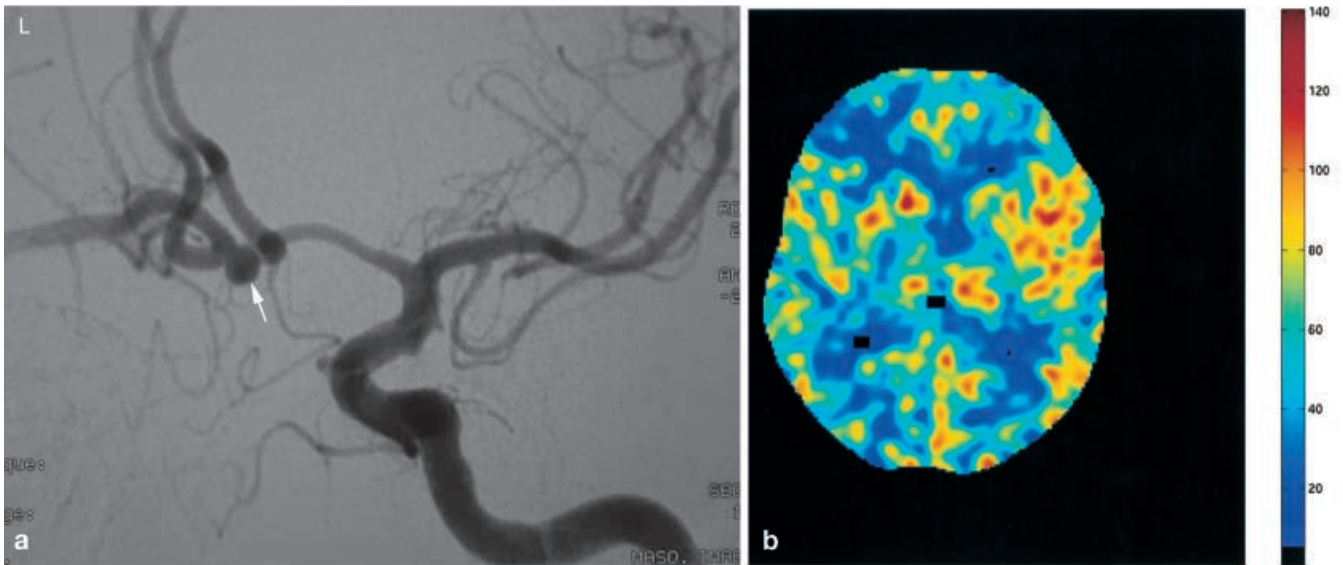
A 53-year-old male patient with chronic arterial hypertension who was admitted to our institution for a subarachnoid hemorrhage. a Lateral angiographic view relates this subarachnoid hemorrhage to a ruptured bilobulated sacciform aneurysm lying on the anterior communicating artery (*arrows*). This aneurysm was clipped surgically. In his follow-up, the patient developed symptomatology of brain ischemia, which justified brain perfusion imaging, i.e., perfusion CT and angiographic studies. The cerebral vessels turned out to be normal. b Stable-xenon CT study obtained 5 min prior to the perfusion CT led to an rCBF map, which can be considered as a reference for comparison, since stable-xenon CT has been validated as an accurate and quantitative technique of rCBF measurement [79, 80, 81]
